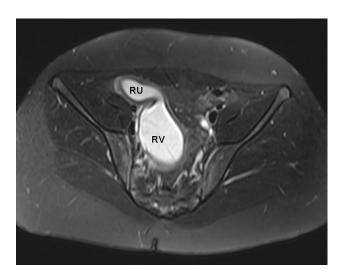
T2-weighted, fat-saturated axial image of the pelvis demonstrates the right uterus (RU) and dilated right vagina (RV).
